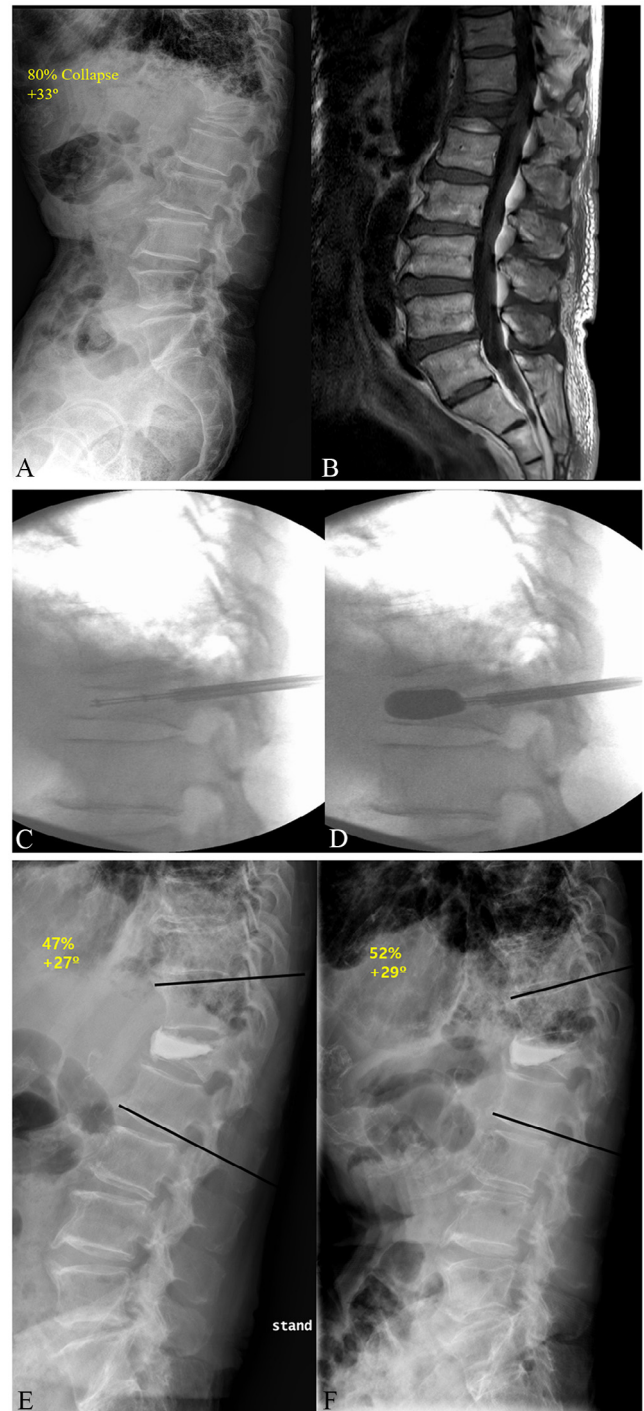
Eighty-eight-year-old male patient who was admitted to our hospital after he slipped down. (A) Plain lateral radiograph shows the osteoporotic vertebral compression fracture of the L1 vertebra with 80% severe collapse and 33° local kyphosis. (B) T1 sagittal magnetic resonance imaging shows an acute recent fracture of the L1 vertebra. (C) Intraoperative fluoroscopy shows a Jamshidi needle (guide pin) inserted in the L1 vertebra. (D) A percutaneous balloon tamp was inflated and reduced the collapse of the vertebral height. Immediate postoperation (E) and 1-year follow-up (F) lateral plain radiograph. The body height and the kyphotic angle improved and remained stable 1 year after the operation.
